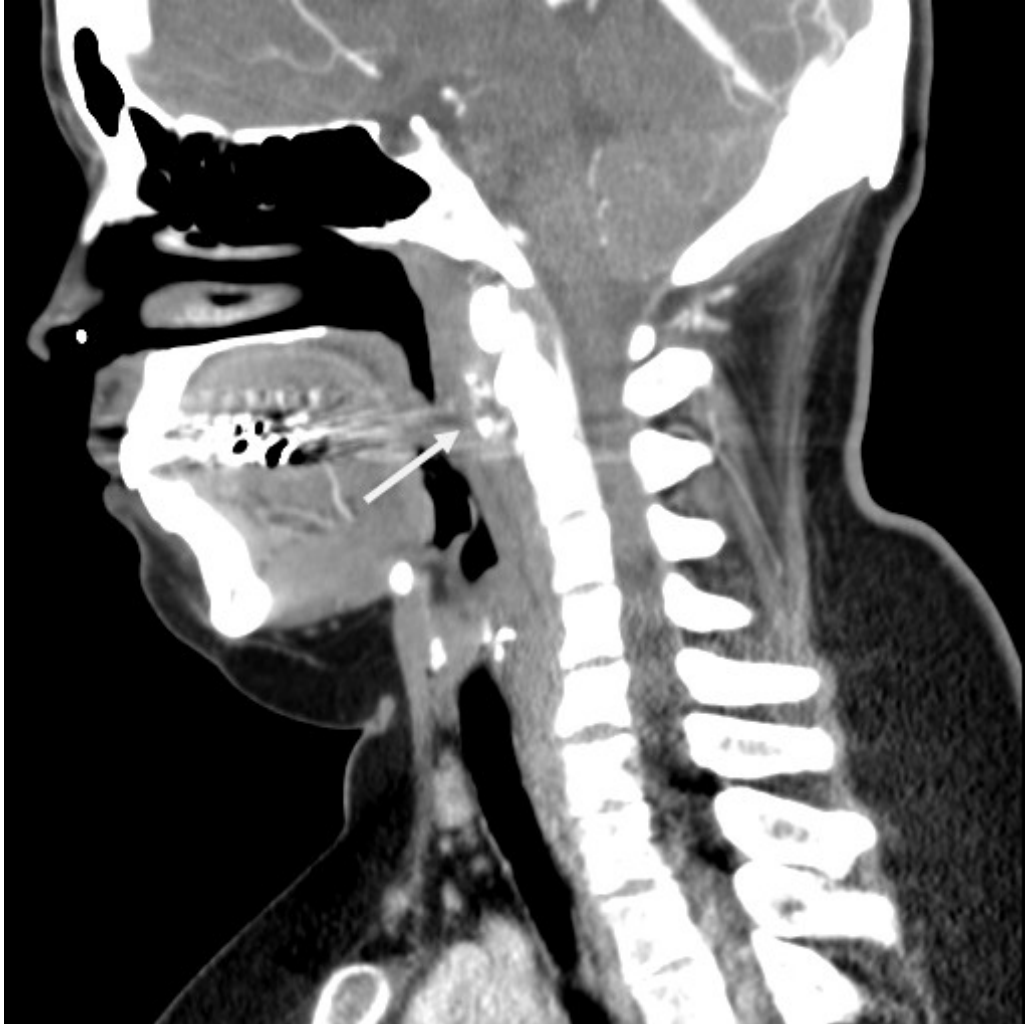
Sagittal CT neck demonstrates focal ring like calcifications (arrow) within the longus colli muscle/tendon.
